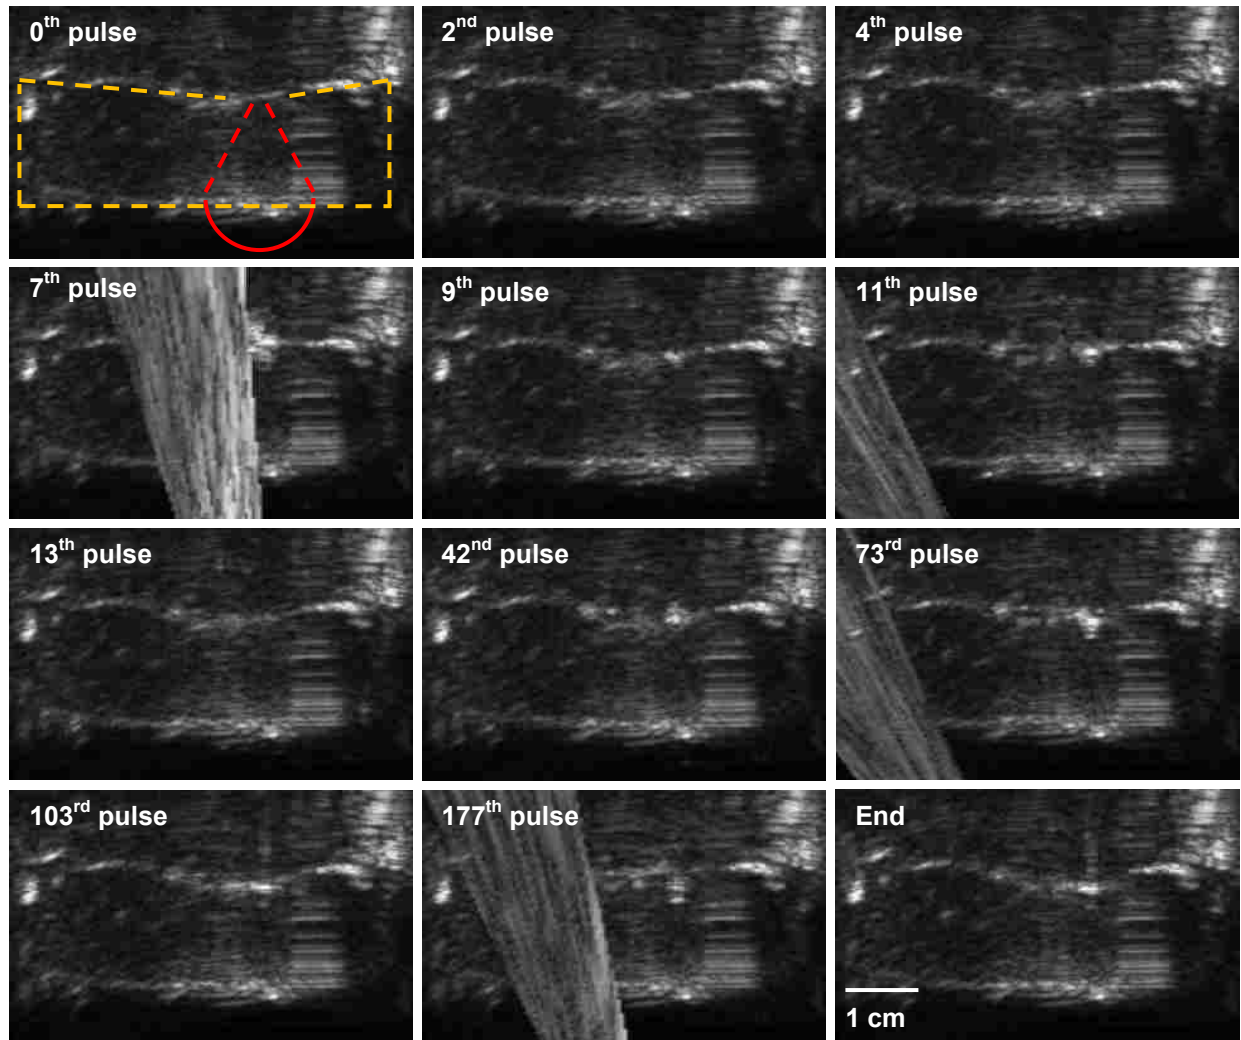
Frames taken from a B-mode ultrasound video of atomization with the 2 MHz HIFU transducer at the maximum *in situ* intensity of $14,000 \text{ W/cm}^2$ ($p_+ = 53 \text{ MPa}$, $p_- = 12.7 \text{ MPa}$). Pulses were 10-ms in duration and repeated at 1 Hz. While the video recording technique precluded the exact timing of atomization, we were able to distinguish which pulse corresponded to which frame, even though discerning the timing within the pulse was not possible. The first frame shows the outlines the tissue sample in yellow, with red indicating the position of the HIFU transducer and the approximate focal location at the tissue surface. The imaging transducer was positioned in the plane of the paper. The second frame shows that the tissue surface was brighter after the second HIFU pulse. By the third frame, or 4th HIFU pulse, we can see a hyperechoic region at the tissue surface. The fourth frame shows interference from the HIFU pulse, and we can see an intense hyperechoic region at the tissue surface just to the right of the HIFU interference. The next two frames (9th and 11th pulses) show the hyperechoic region getting larger and more intense, yet by the 7th frame (13th pulse) the hyperechogenicity is gone. We expect that this frame was taken near the end of the HIFU off-time, as it appears that bubble activity has ceased. The frames corresponding to the 42nd, 73rd, 103rd, and 177th pulses show the growth of the hyperechoic region at the tissue surface as the pulse number increases. The final frame shows that the hyperechoic region at the surface remains, even several seconds after the last HIFU pulse, and corresponds to the hole that was formed in the tissue surface.
